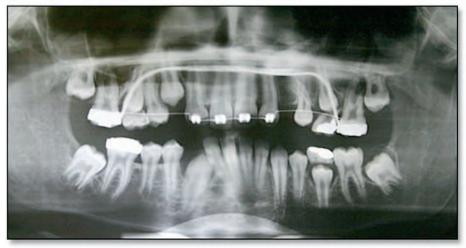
Panoramic radiograph at age 13 years 10 months.
